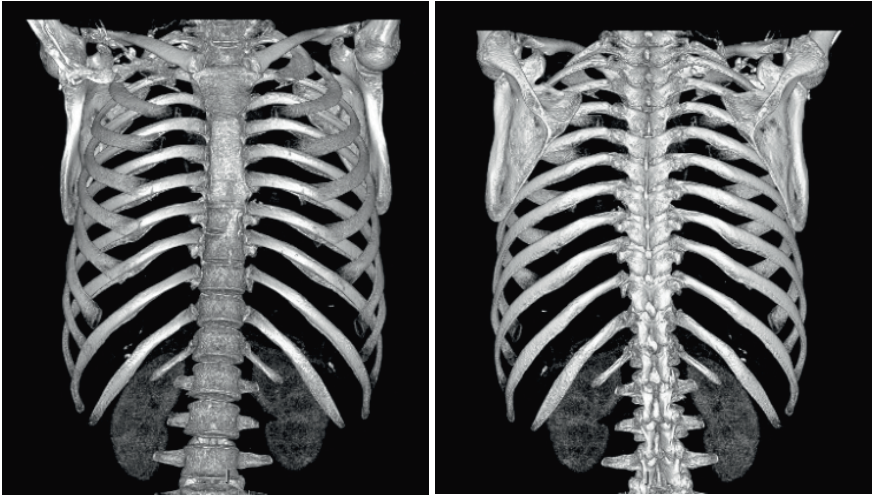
Anterior (left) and posterior (right) 3D images of CT Thorax.
